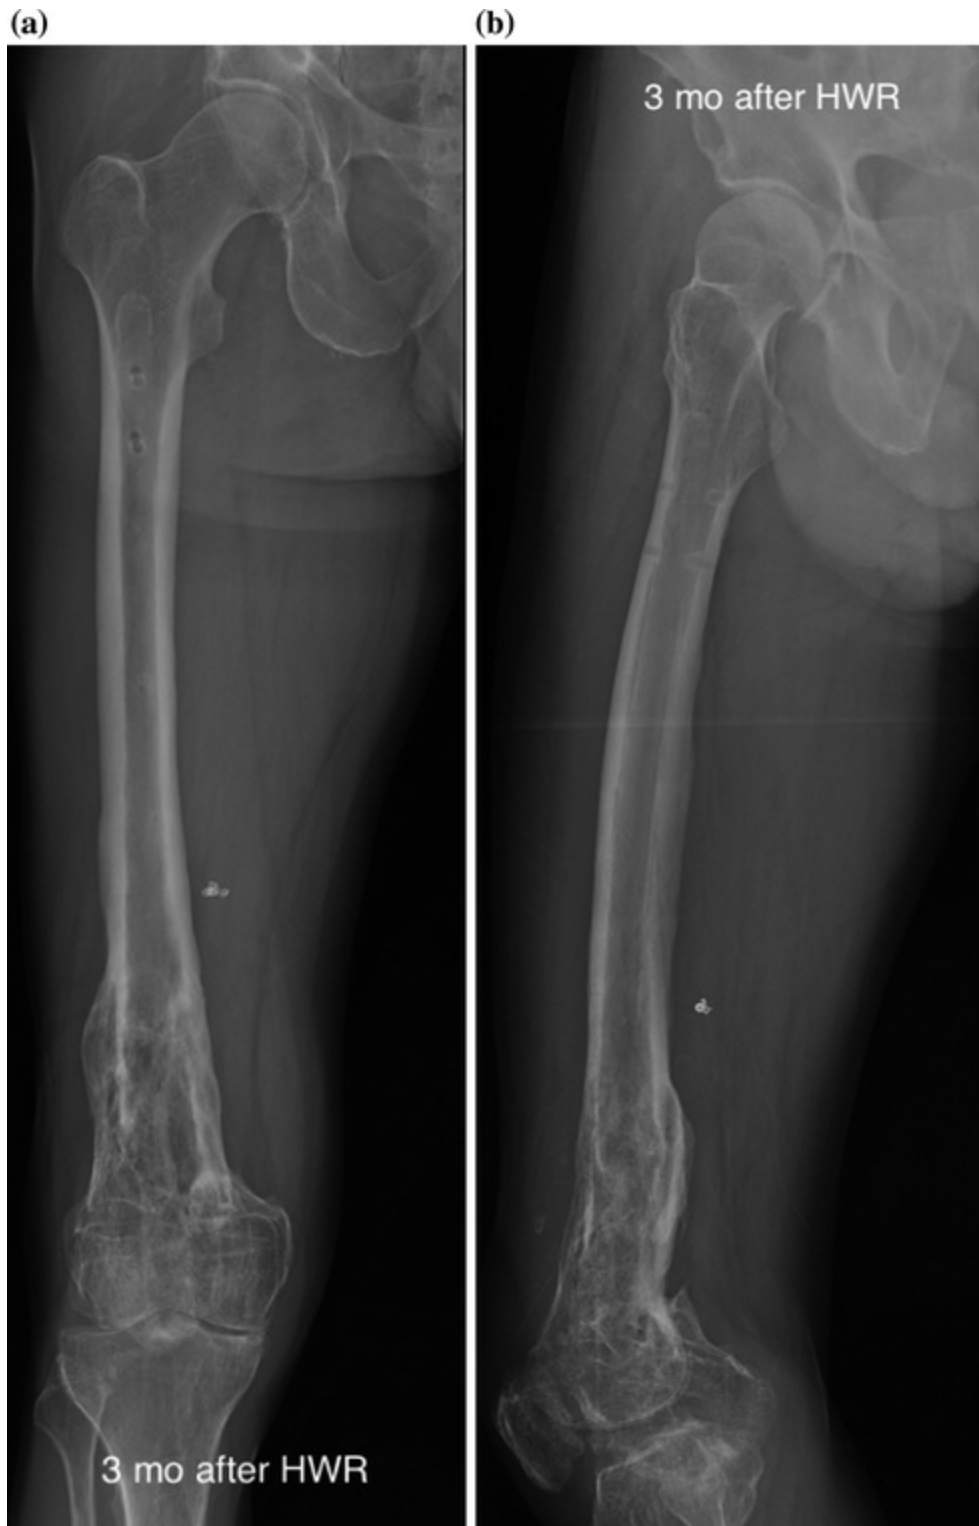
a Anteroposterior and b lateral radiographs of the right femur at 3 months after hardware removal
